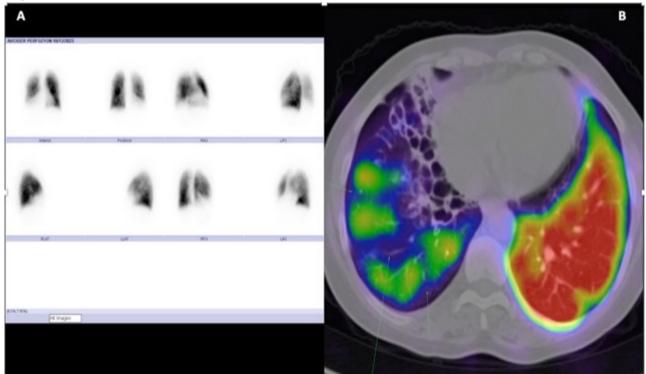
52 years old female patient with median lobe defects in planar images (a) and match defect at this segments as well as anterior lateral and posterior basal segment mismatch defects in SPECT-CT images (b).
